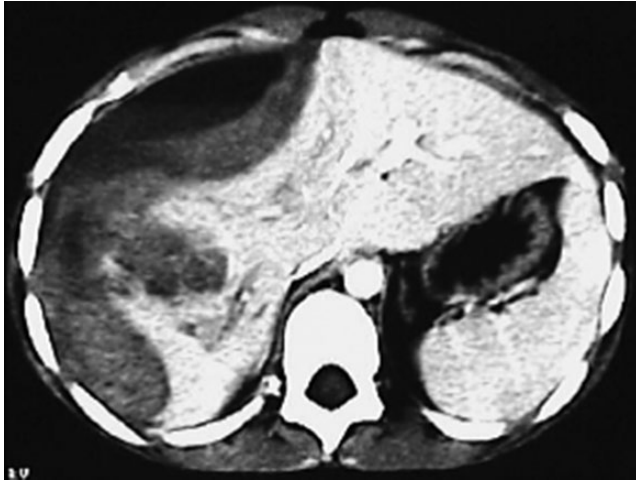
Abdominal contrast CT scan of a 10-year-old girl with massive subcapsular hematoma, partially liquefied.
